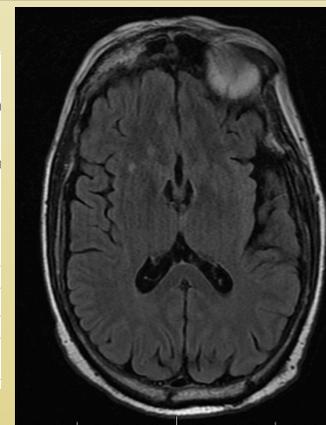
Pt's T2 FLAIR MRI brain w/ no increased signal
